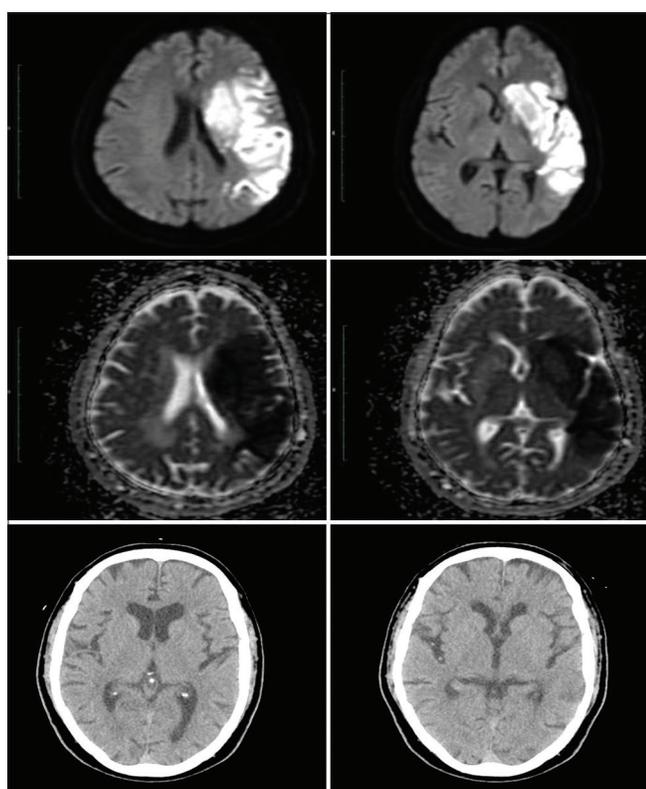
Magnetic resonance imaging-diffusion-weighted imaging apparent diffusion coefficient (ADC) image shows restriction in the left caudate nucleus, left internal capsule, M1, M2, M3, M4, and M5 with corresponding reduced diffusivity in ADC map in middle cerebral artery distribution in a patient who had normal non contrast computed tomography head
